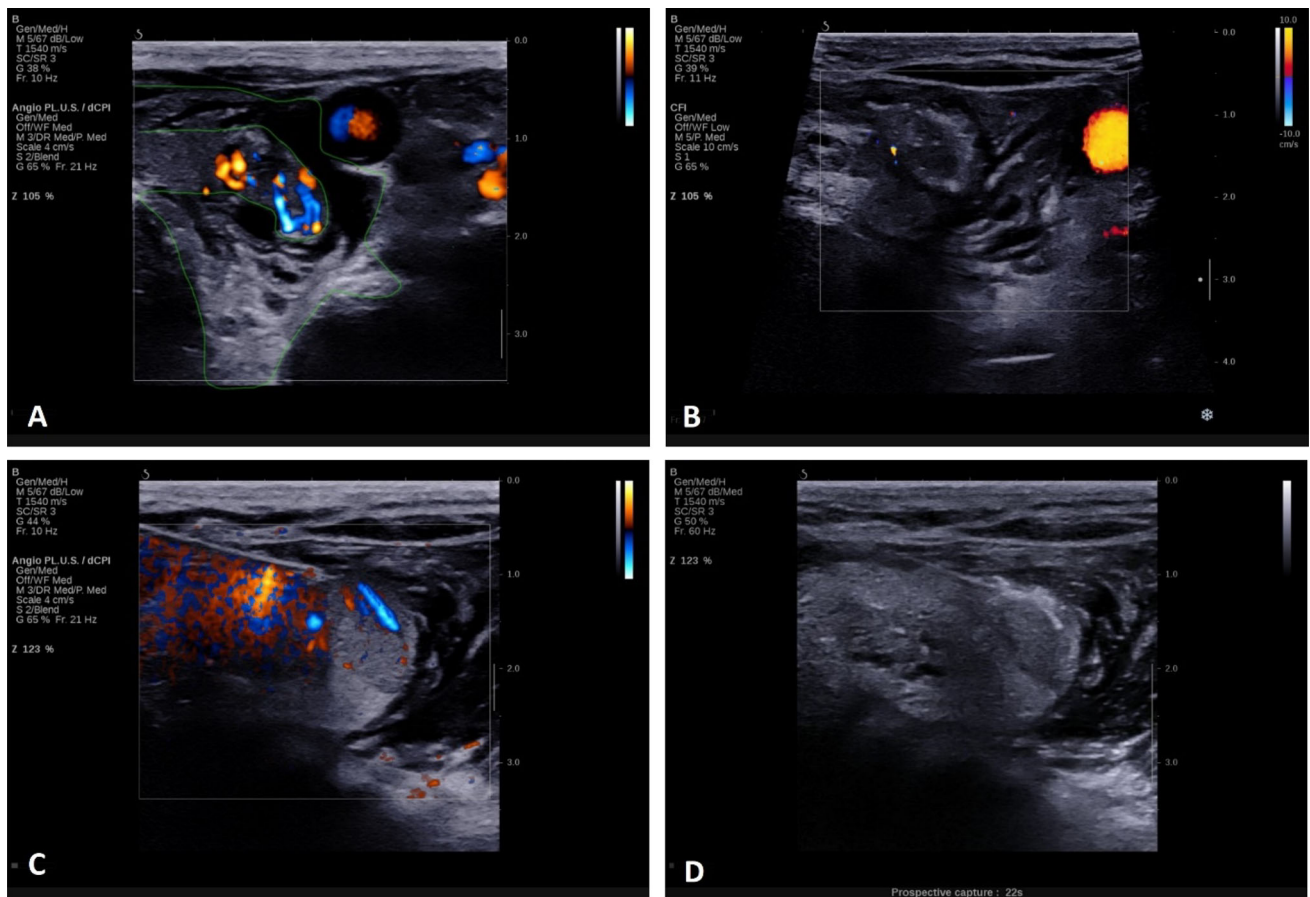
Ultrasonographic features of radiofrequency ablation (RFA). A. Sonography features showed full dissection method and hyper-vascular parathyroid adenoma (PTA) before RFA. B. Avascular PTA
